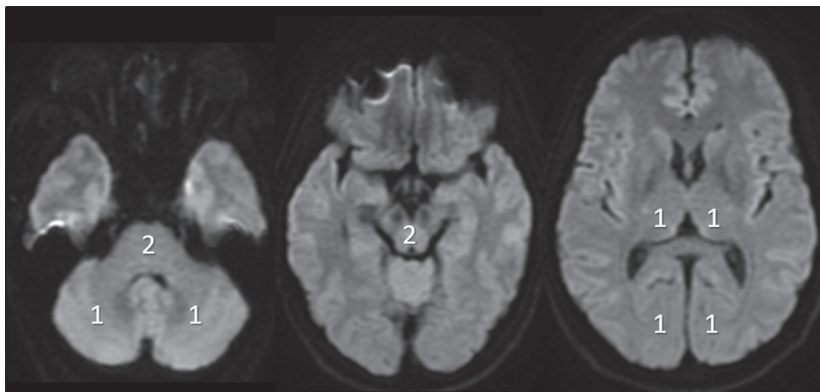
pcASPECTS system. Each thalamus and occipital region corresponding to the PCA territories is given 1 point each. The midbrain and pons densely populated by gray matter nuclei and white matter tracts are given 2 points each. The cerebellar hemispheres are given 1 point each. Similar to the ASPECTS, points are deducted from a baseline maximum of 10.
